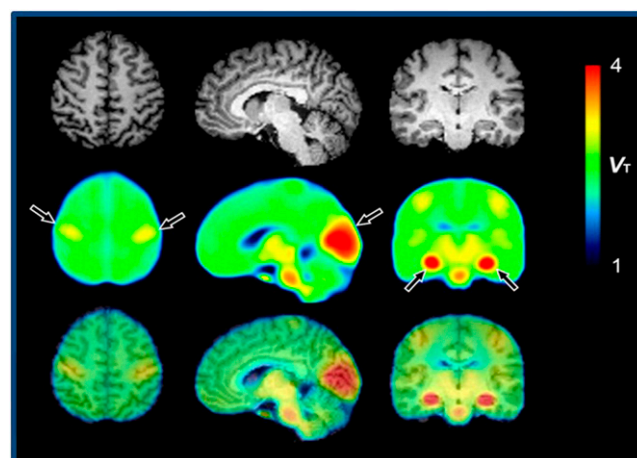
^{11}C -PS13 for imaging COX-1 in brain and peripheral organs. Representative ^{11}C -PS13 brain PET images (middle row) in a healthy subject. High uptake was seen in the bilateral hippocampus and occipital cortices as well as bilateral pericentral cortices. Top row: MR images. Bottom row: fusion images. These data provide initial evidence for ^{11}C -PS13 as a tracer of COX-1, as a probe for assessing neuroinflammation, and as an agent to determine target engagement by therapeutic drugs.
